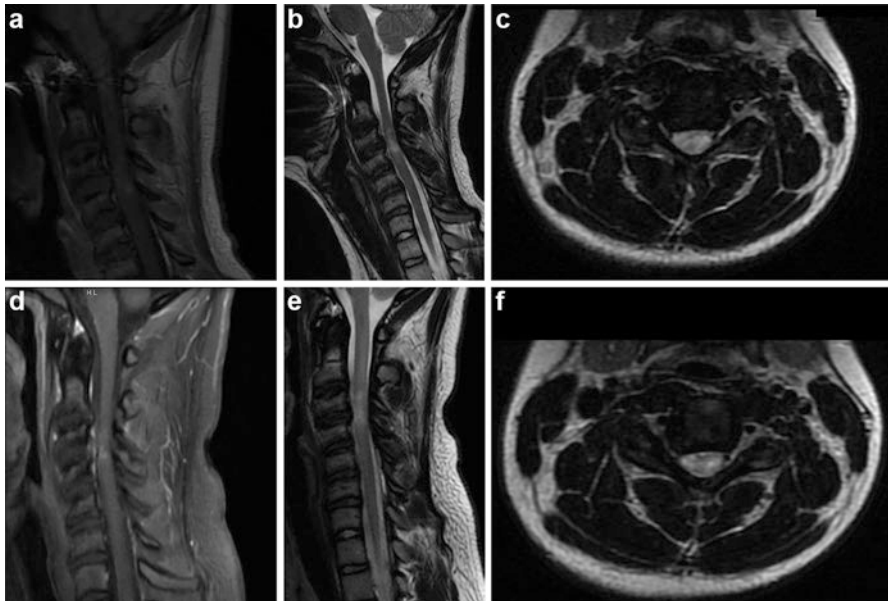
MRI sagittal T1 post-contrast (*left*) and T2 sequences (*middle and right*) of cervical spine at presentation (a–c) and 5 months later (d–f). The T2 signal hyperintensity extending from C3 to C4 persists, while enhancement is slightly increased on follow-up. Note also mild disc protrusion at C3–C4, mild disc desiccation, and cervical canal narrowing, which are surprising findings for a 16-year-old girl
